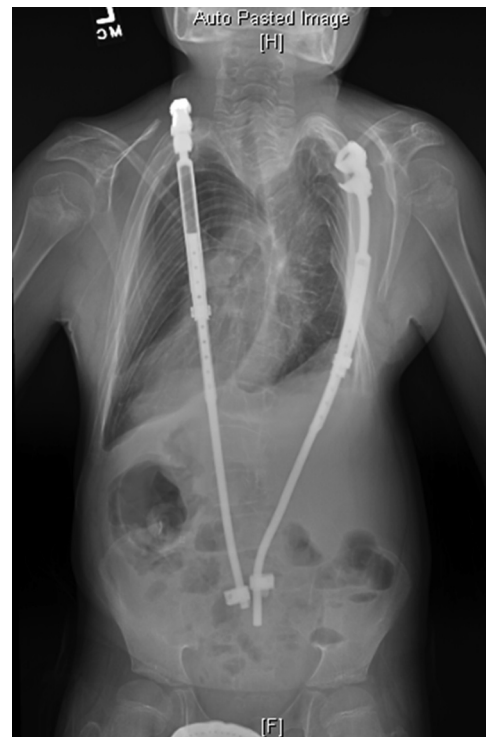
Posteroanterior radiograph of carbon-coated implants in place, controlling scoliosis 4 years 10 months after implantation.
